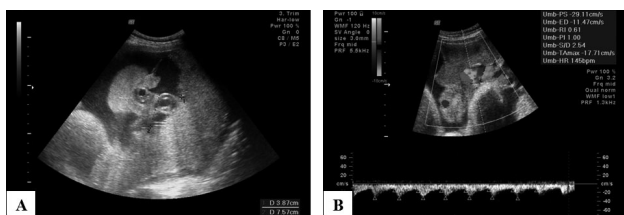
Hyperechogenic structure of dimensions 3.87×7.57 cm localized around the fetal end of the umbilical cord and presenting no Doppler flow (A). Ultrasound examination: normal-resistance flows in the umbilical artery (UmbA PI = 1.00) (B).
